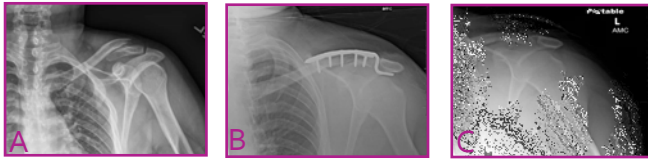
Radiographs of a 21-year-old man with a distal clavicle fracture resulting from a collision on a mountain bike, showing anteroposterior-view progression of operative treatment using hook plates. (A) Preoperatively. (B) Intraoperatively, with the hook plate fixed onto the clavicle. (C) Postoperatively, with successful healing after removal of the hook plate.
